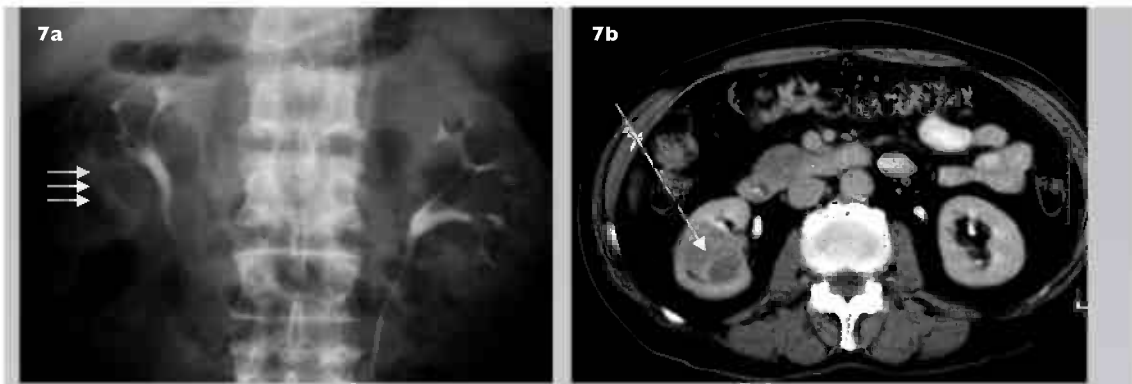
(a) Intravenous urogram coned image shows absence of the lower pole calyces due to a space-occupying lesion (arrows), compared to the opposite side. (b) Corresponding axial CT image shows RCC in the lower aspect of the right kidney (arrow).
